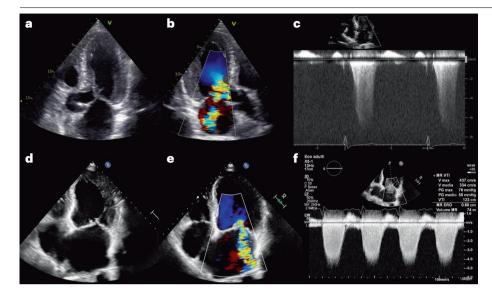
Mitral regurgitation in hypertrophic and dilated cardiomyopathy. a-c, 2D transthoracic echocardiography of a patient with hypertrophic cardiomyopathy. a, Apical five-chamber view showing asymmetric septal hypertrophy and systolic anterior motion (SAM) of the anterior mitral valve leaflet. b, Colour Doppler threechamber view showing SAM-related severe mitral regurgitation. c, Continuous-wave Doppler showing SAM-dependent mitral regurgitation signal. d-f, 2D transthoracic echocardiography of a patient with dilated cardiomyopathy. d, Apical four-chamber view showing a dilated left ventricle and left atrium. e, Colour Doppler apical fourchamber view showing severe functional mitral regurgitation. f, Continuous-wave Doppler showing functional mitral regurgitation signal. CF, color flow; CW, continuous wave; MR ERO, mitral regurgitation effective regurgitant orifice; PG, pressure gradient; VTI, velocity time integral; WF, wave frequencies.
